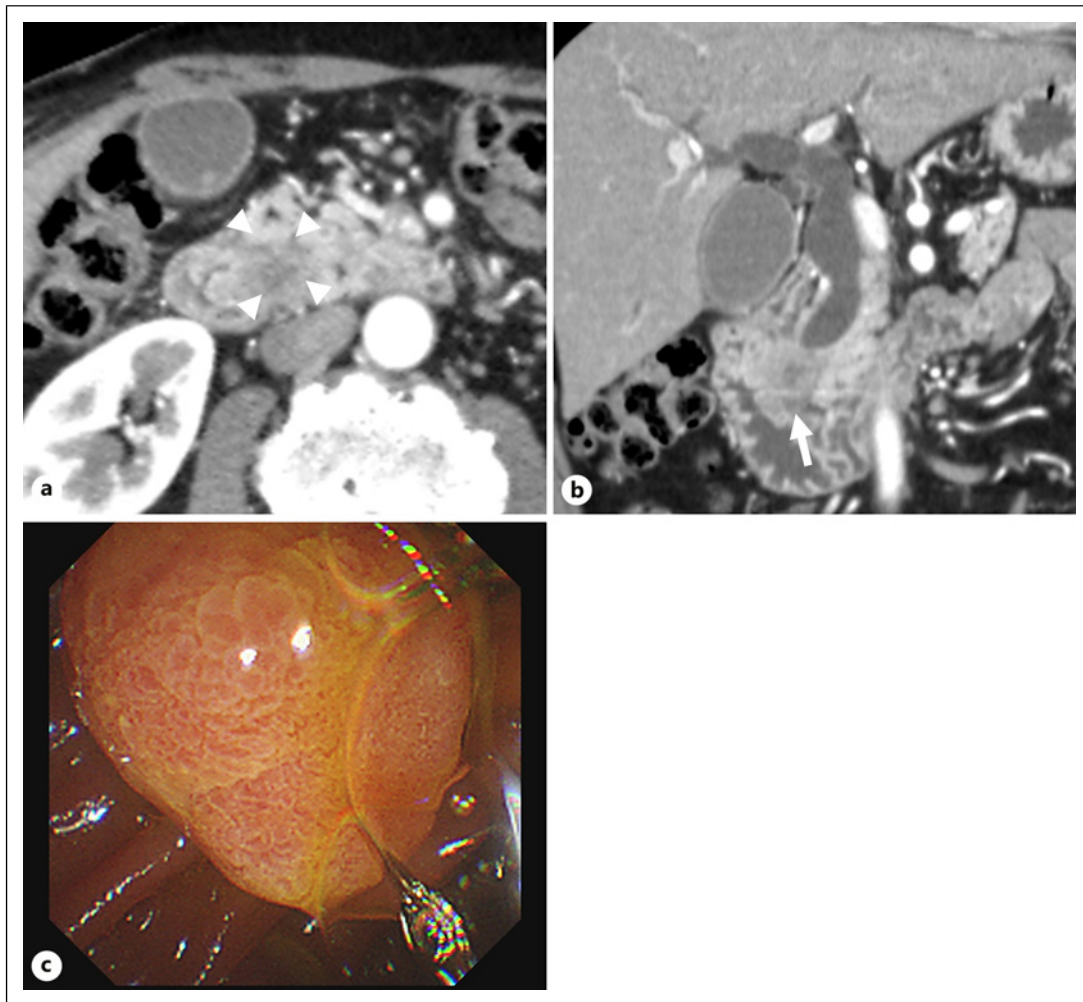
Preoperative contrast-enhanced computed tomography and endoscopic findings. a Axial section of computed tomography. The tumor is seen as a lower density lesion during the portal phase (surrounded by arrowheads). b Coronal section of computed tomography. Both intrahepatic and extrahepatic ducts are dilated because of obstruction caused by the tumor of the AmV (arrow). c Endoscopic image. The AmV shows inflammation.
